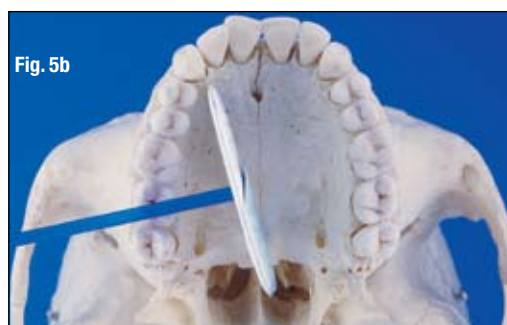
5b_ Path of the X-rays in the distomesial projection.
